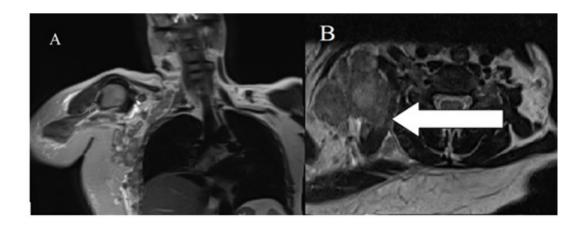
MRI images showing extensive involvement of the right brachial plexus. In A (coronal) and B (axial) T1-weighted sequences showing an infiltrating mass encasing the right brachial plexus.
